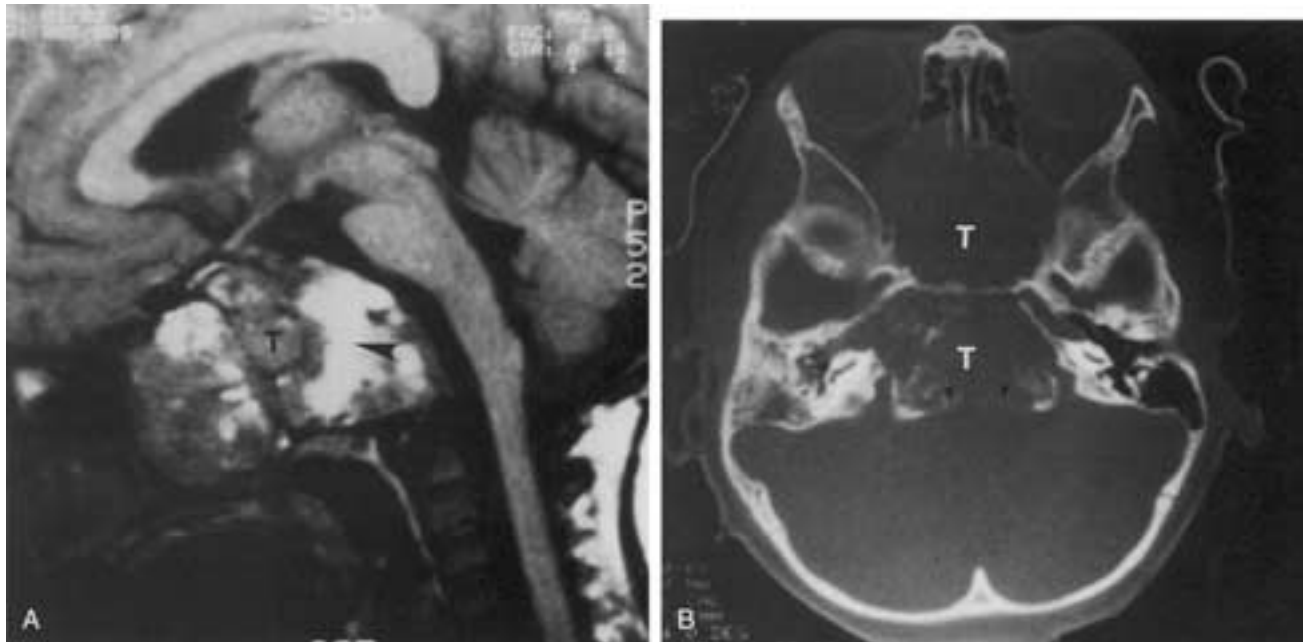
A, Chordoma of the skull base. Sagittal image shows the tumor replacing the sphenoid sinus. The tumor (T) has both intermediate and high (large black arrowhead) areas of signal intensity. Chordomas can have a variety of appearances, including areas of high signal representing either cystic areas or hemorrhage. B, Axial CT image shows the tumor with both anterior and posterior components (T). The expansion of the clival surface (arrowheads) is seen posteriorly.
